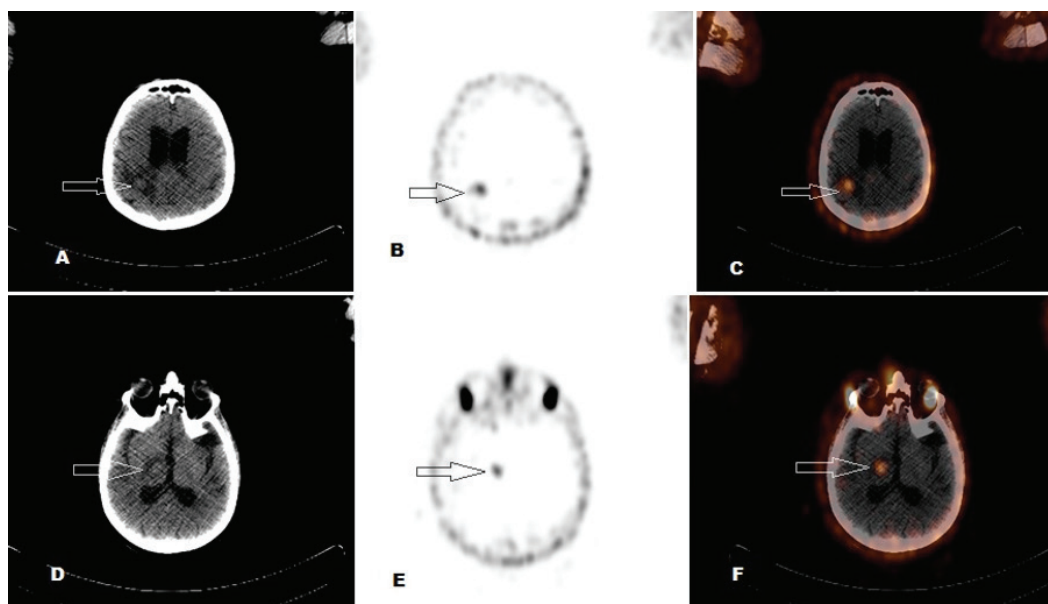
In prostate cancer, correct evaluation of extraprostatic spread is of great importance for estimated prognosis and in treatment planning. The most common areas of metastasis are pelvic lymph nodes and bone (1). Hatzoglou et al. (2) identified the incidence of brain metastasis from prostate carcinoma as 0.16%. They also stated that non-adenocarcinoma pathology are more likely to develop brain metastasis (2). Gallium-68- ^{68}Ga prostate-specific membrane antigen (PSMA) positron emission tomography/computed tomography (PET/CT) (Philips, True Flight Select, USA) scan was performed on a 62-year-old patient with prostate adenocarcinoma (Gleason's score 4+3, PSA 12.2 ng/mL). ^{68}Ga PSMA avid lesions in the right parietal (A, B, C) and thalamic (D, E, F) regions with perilesional edema were detected [maximum standardized uptake value (SUV_{max}): 1.3-2.6] (arrow). Magnetic resonance imaging (MRI) was performed for further evaluation. MRI report was consistent with our findings, demonstrating a 2 cm diameter mass in the right frontal lobe-precentral gyrus localization with peripheral diffusion restriction and a similar lesion in the right thalamus with a diameter of 1.3 cm. Radiotherapy was planned for cranial metastases.
